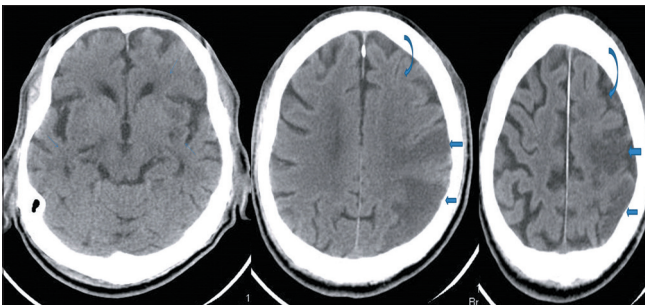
Head computed tomography showing multiple infarcts involving left frontal (left curved arrow), parietooccipital (block arrow) and multiple lacunar infarcts in bilateral gangliocapsular regions involving the left caudate nucleus, right lentiform nucleus and bilateral external capsules (arrow)
